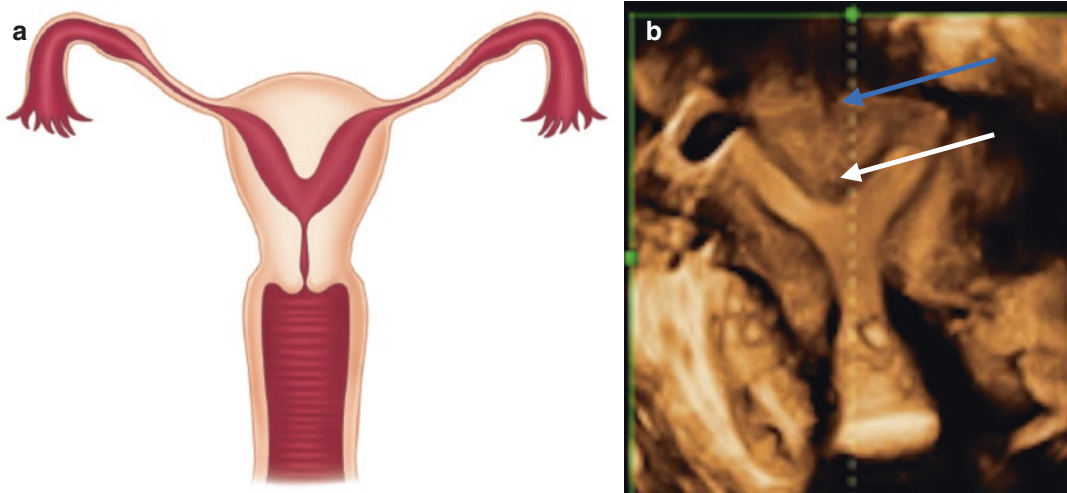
Partial uterine septum. (a) Depiction of partial uterine septum. (b) 3D ultrasound image of partial uterine septum (Blue arrow: Normal fundal uterine contour) (White arrow: Partial uterine septum)
